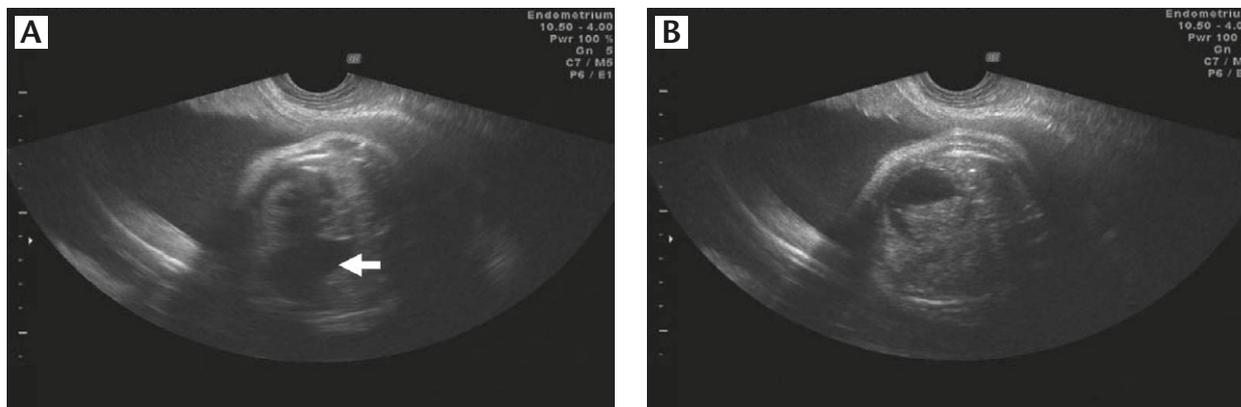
Ultrasound image of the thoracic cavity (white arrow denotes the misplaced stomach) in a 29-week gestational age fetus with congenital diaphragmatic hernia (A) before and (B) after cardiac tamponade.
